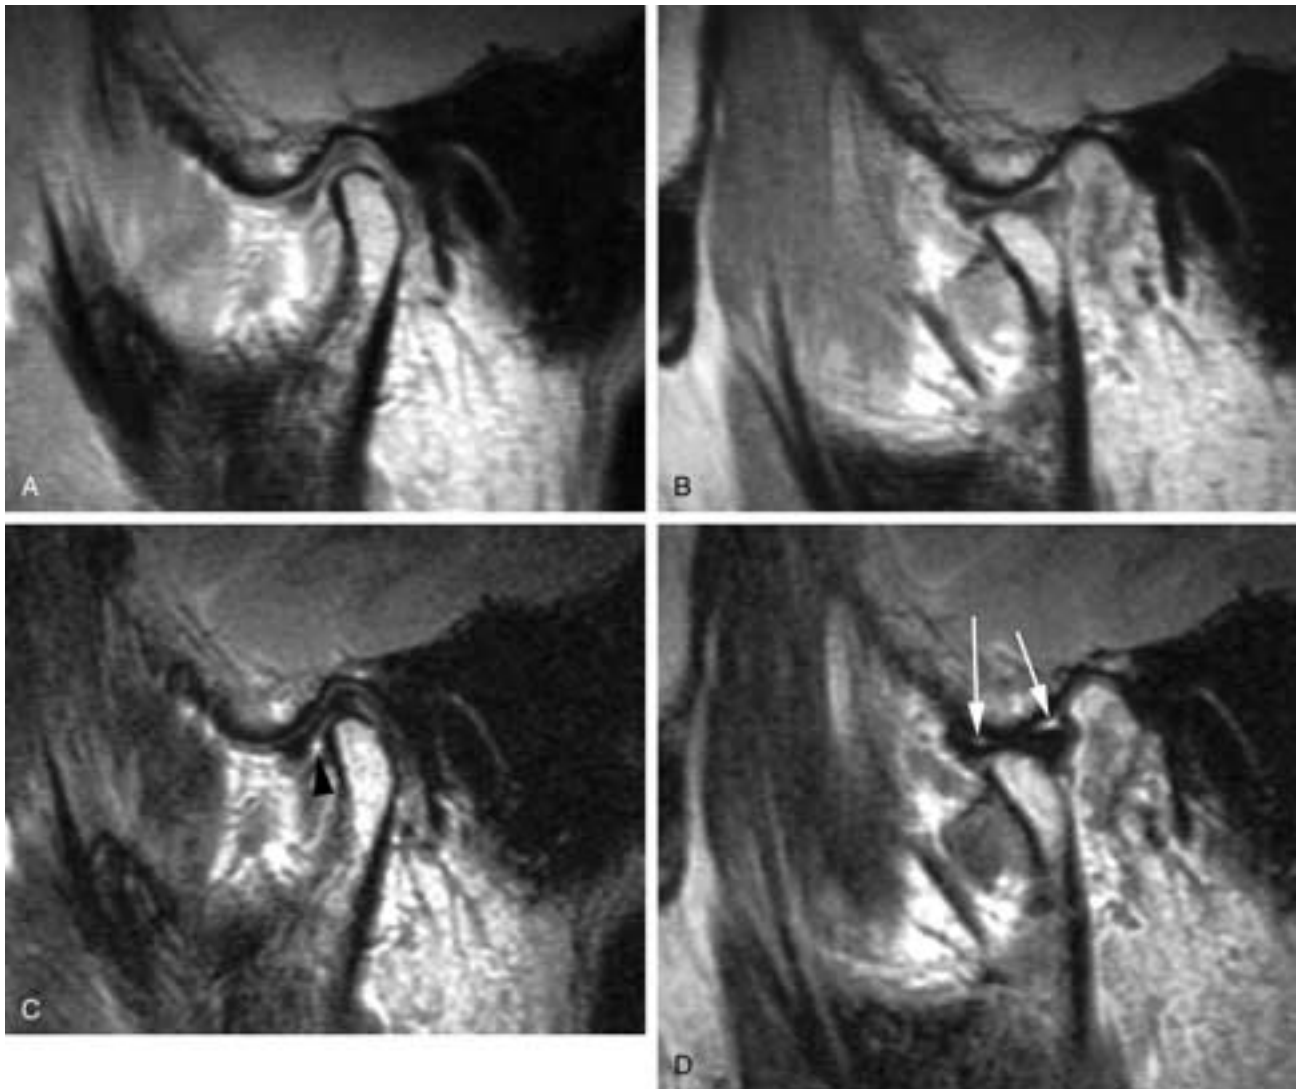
Normal TMJ with minimal joint fluid. A, Proton density image, closed-mouth position. The disk is seen in the normal location. The condyle is in the normal position relative to the glenoid fossa. B, Open-mouth position. The disk and condyle have translated downward beneath the articular eminence. C, T2-weighted image, closed-mouth position. A very small amount of high signal (*arrowhead*), which may represent a small amount of fluid in the anterior recess of the inferior joint space. D, T2-weighted image, open-mouth position, shows a small amount of fluid (*arrows*) in the superior joint space.
